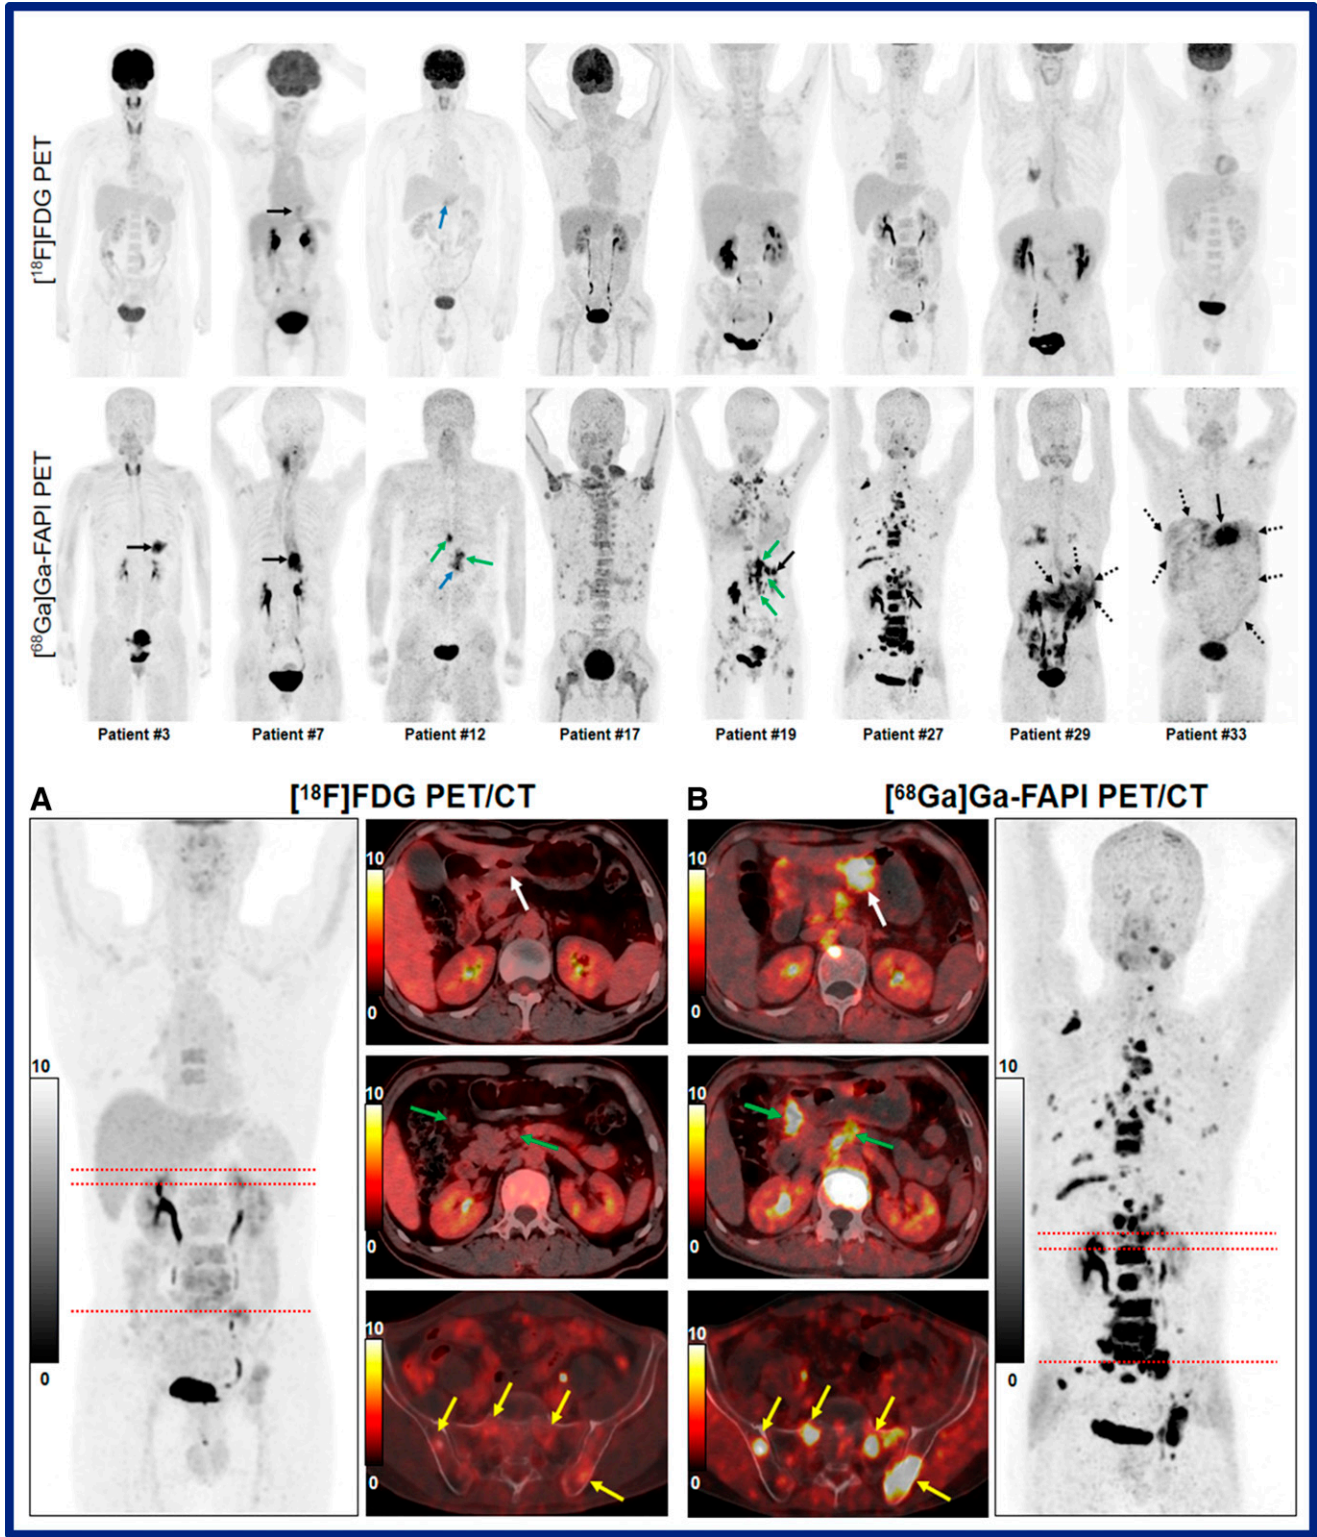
Comparison of ^{68}Ga -FAPI and ^{18}F -FDG PET/CT in gastric signet-ring cell carcinoma. Top: Example patients imaged with ^{18}F -FDG (top row) and ^{68}Ga -FAPI (bottom row) PET/CT. Bottom: Comparative imaging in a single patient with ^{18}F -FDG (left) and ^{68}Ga -FAPI (right) PET/CT. ^{68}Ga -FAPI imaging resulted in higher detection rates in primary tumors (73% vs 18%), local recurrence (100% vs 29%), nodal metastases (77% vs 23%), and distant metastases (93% vs 39%).
